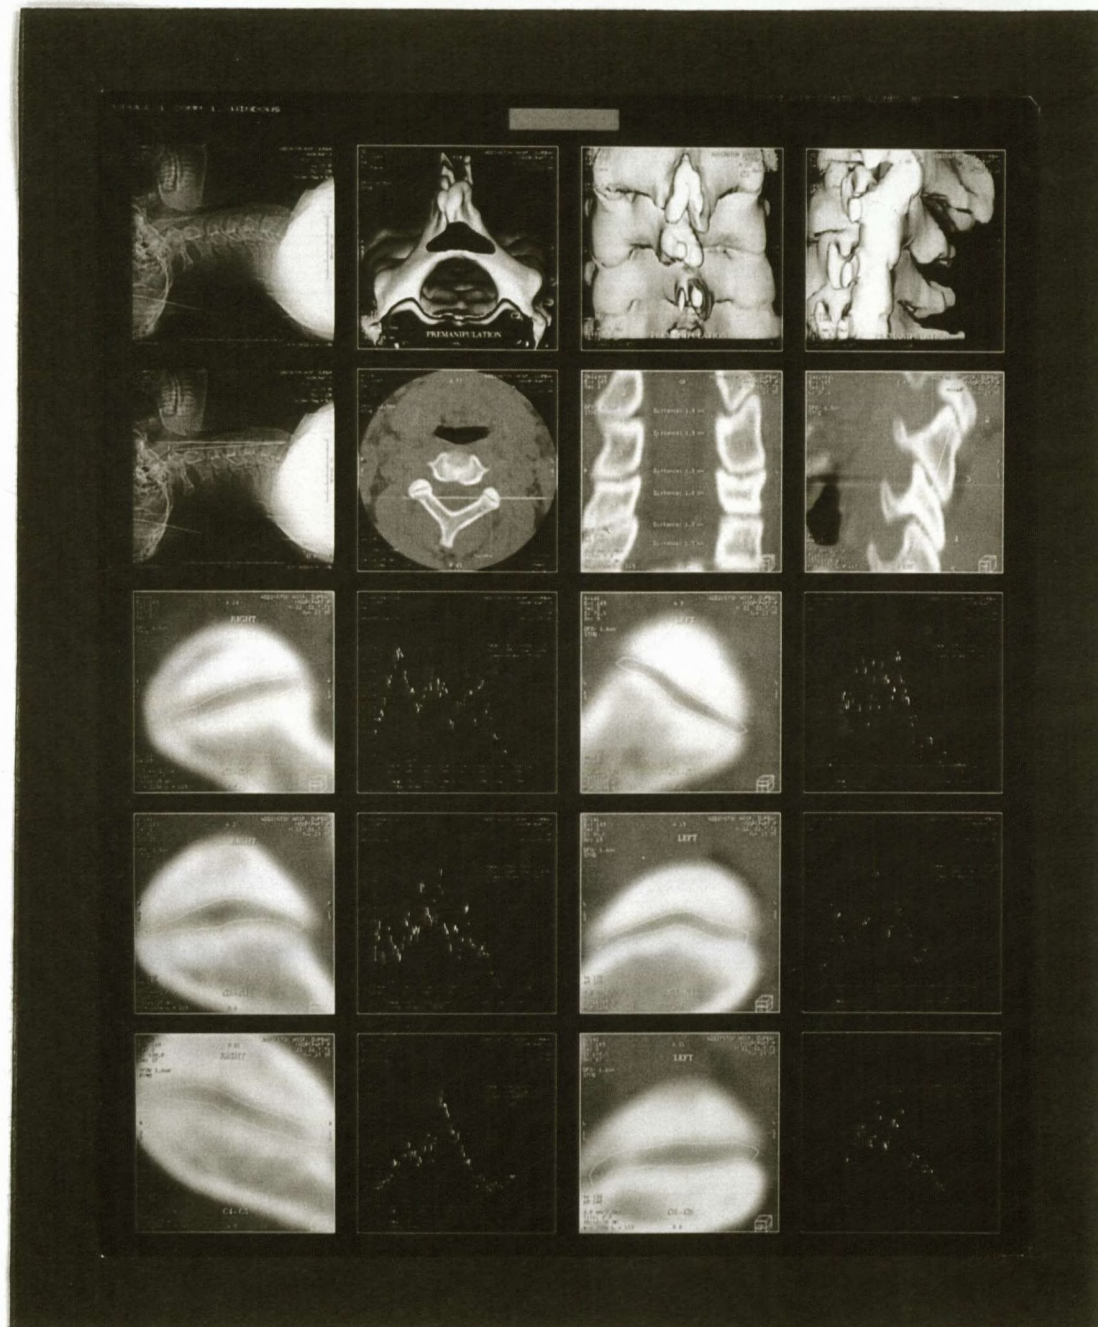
Experiment 3 : Pre-manipulation + 5kg traction CT scan
